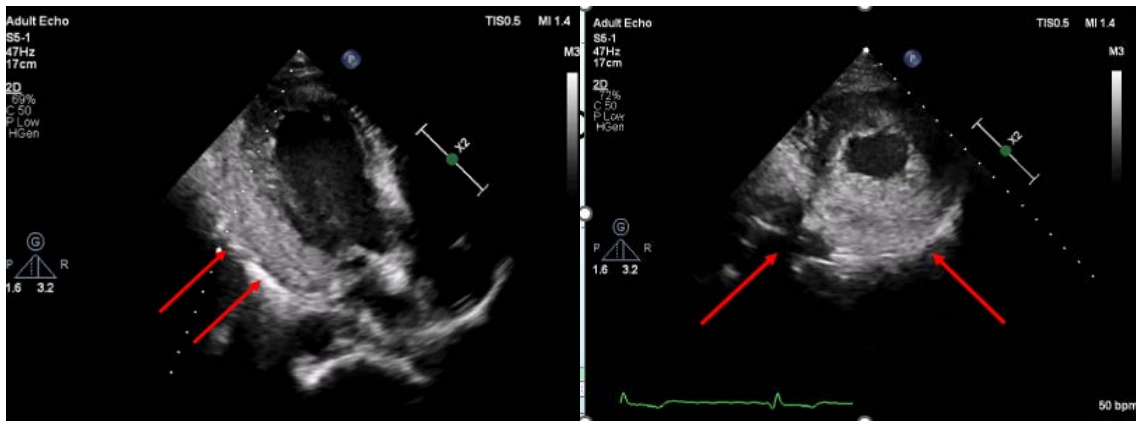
Echocardiographic changes in Fabry disease progression with myocardial involvement. A. Speckle-tracking echocardiography, reduced basal segment shortening function on the left ventricular inferior wall, preserved apical segment shortening function. B. Apical four-chamber view, visible atrial enlargement, concentric thickening and granular echostructure of the left ventricular muscle. C. Modified apical two-chamber view — marked hypertrophy of the left ventricular inferior wall can be seen D. Transverse apical view — marked hypertrophy of the apical segments of the inferior wall can be seen
